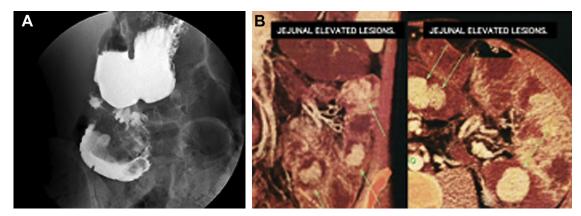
(A) Upper gastrointestinal series confirms the presence of large polyps at the duodenum. (B) Computed tomography enterography shows large lesions at the jejunum.
